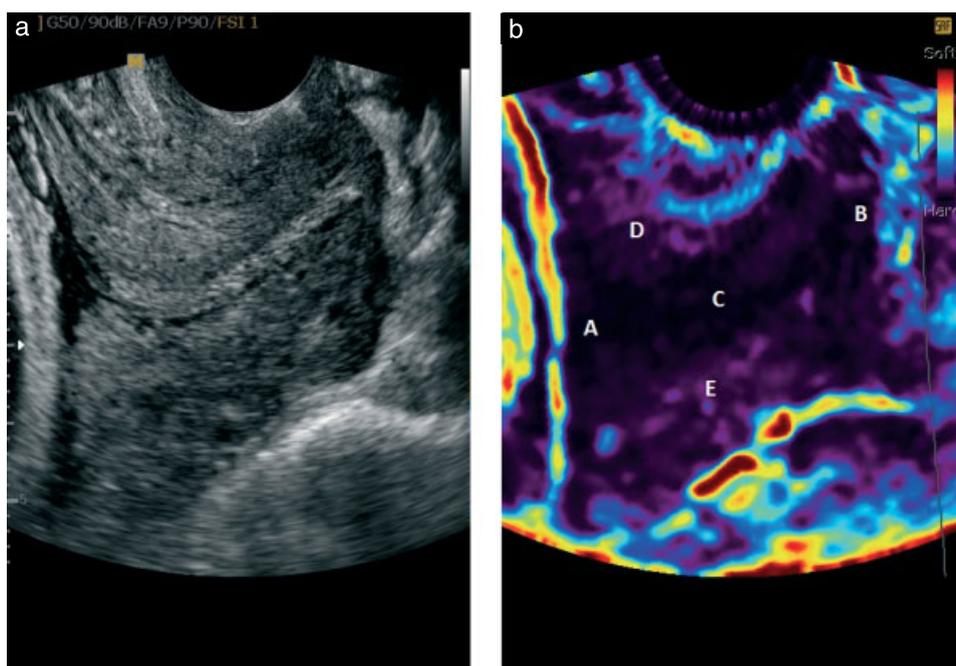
Elastography of the uterine cervix with hard cervical canal and orifices. (a) Gray-scale ultrasound image of the uterine cervix. (b) Elastogram showing that the entire cervix is the same color, representing the same stiffness. A, internal os; B, external os; C, cervical canal; D, anterior wall of the cervix; E, posterior wall of the cervix.
